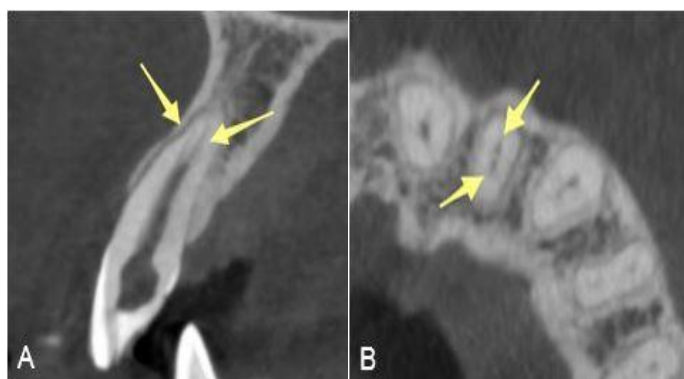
A) CBCT scan of the maxillary left lateral incisor; A) Sagittal view; B) Axial view shows the bifurcation of canals in the apical third
